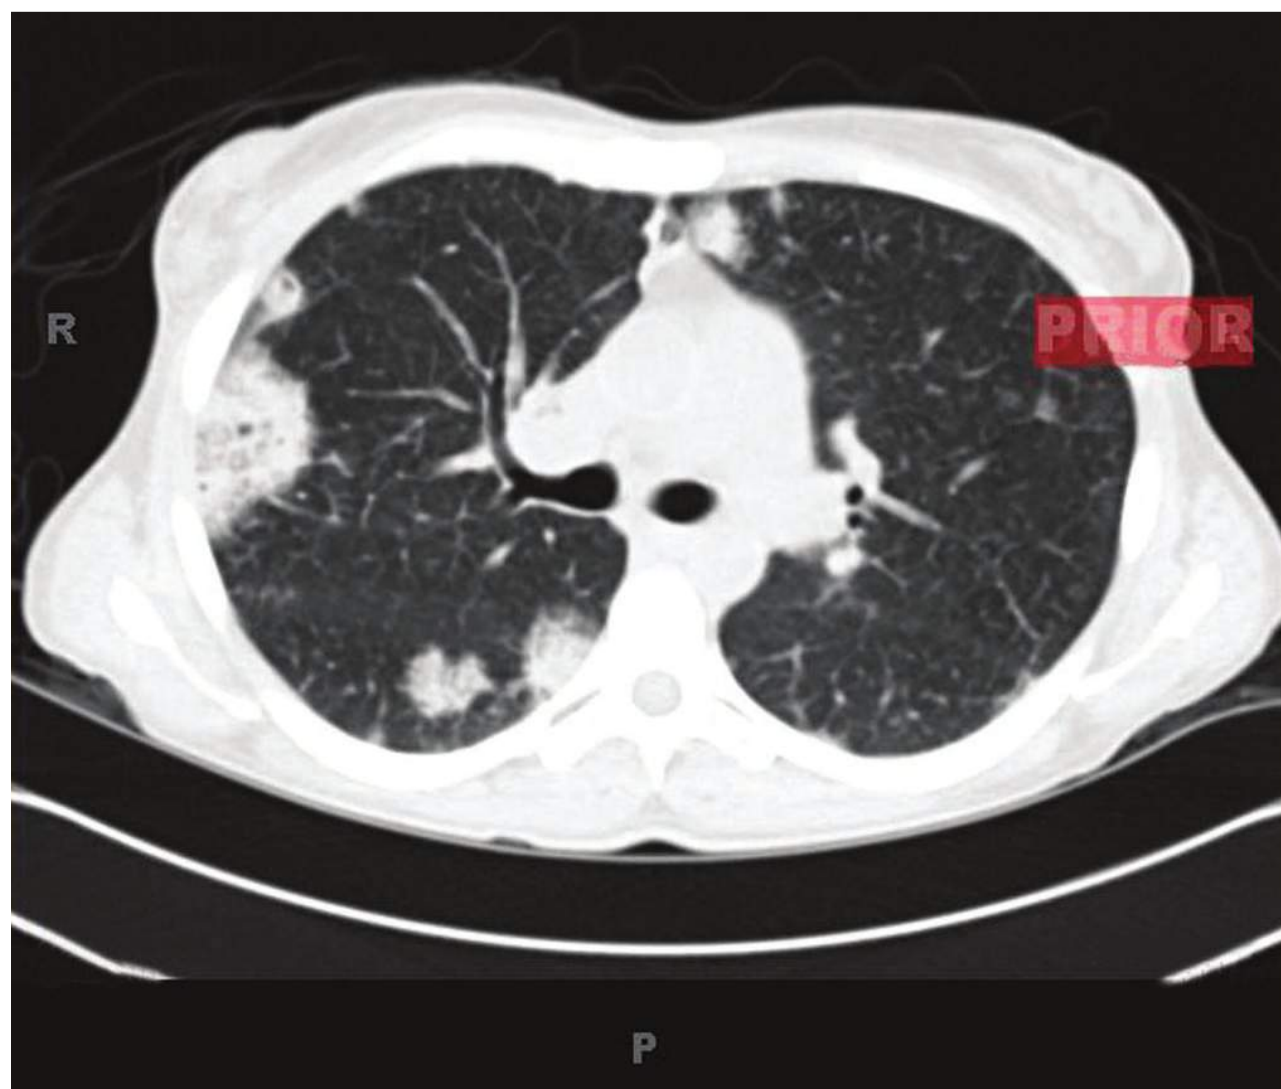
Chest CT of IVDA patient with tricuspid valve endocarditis due to *Staphylococcus aureus* showing multiple pulmonary emboli, some with early cavitation.
